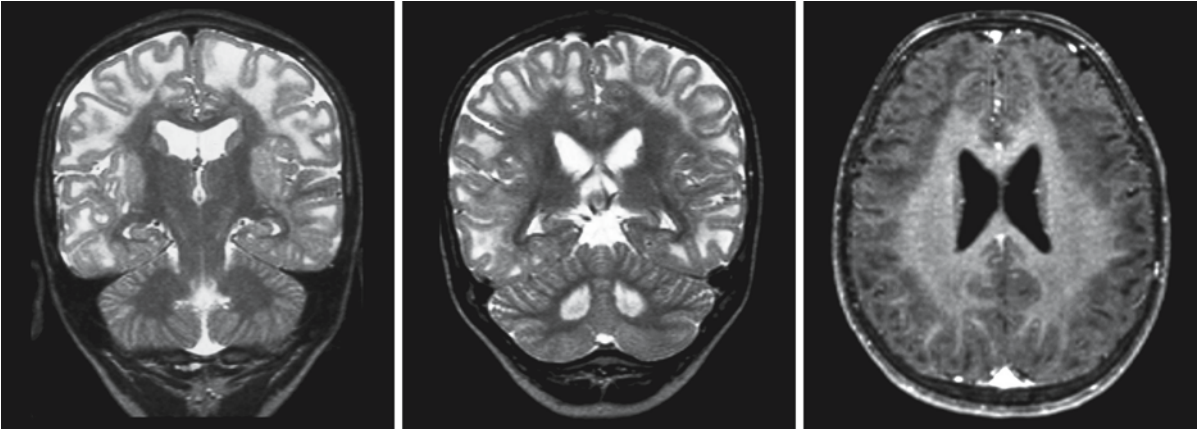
MR images of a 10-year-old boy with L-2-hydroxyglutaric aciduria, showing confluent involvement of the subcortical white matter, which is also mildly swollen. The central
